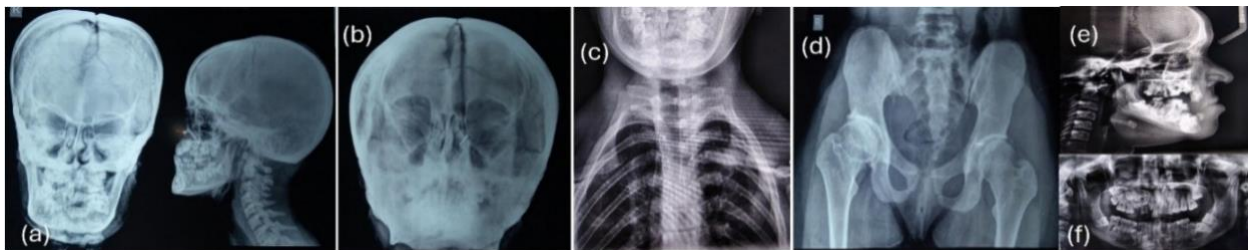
(a) Anteroposterior view of skull showing sunken sutures and depressed calvaria, Lateral view of skull shows open coronal suture, hypoplastic maxilla, prognathic mandible, frontal bossing (b) Paranasal sinus view showed possible hypoplastic bilateral maxillary sinus, multiple Wormian bones, open sagittal suture (c) Postero-anterior chest radiograph showing hypoplastic clavicles. Two separate hypoplastic segment noted in left side. Oblique orientation of ribs. Narrow bony thorax. (d) Radiograph of pelvis revealed wide pubic symphyseal space and shortened neck of right femur with osteoarthritic changes in right hip joint (e) Lateral cephalometric showing multiple unerupted permanent teeth, supernumerary teeth Hypoplastic maxilla and prognathic mandible and midface deficiency (f) OPG shows supernumerary teeth, multiple impacted teeth and over retained primary teeth.
